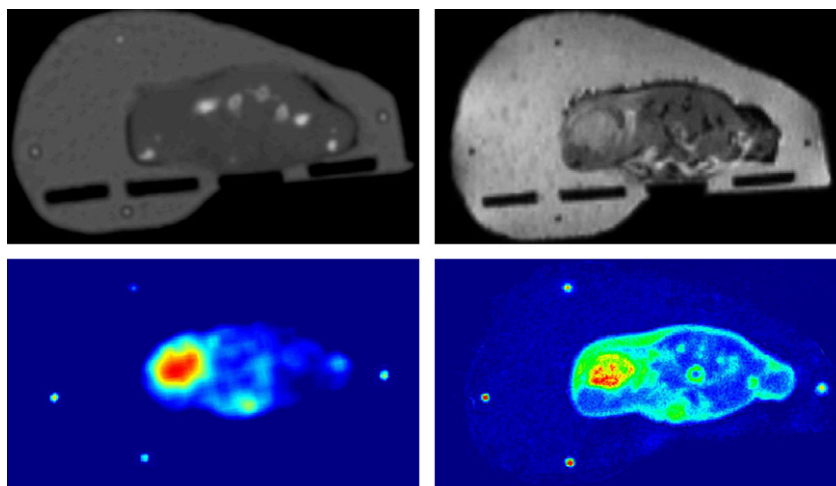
Transversal view of the immobilization device imaged with CT, MRI, PET and autoradiography. The Teflon[®] tube sections are clearly visible on all modalities.
